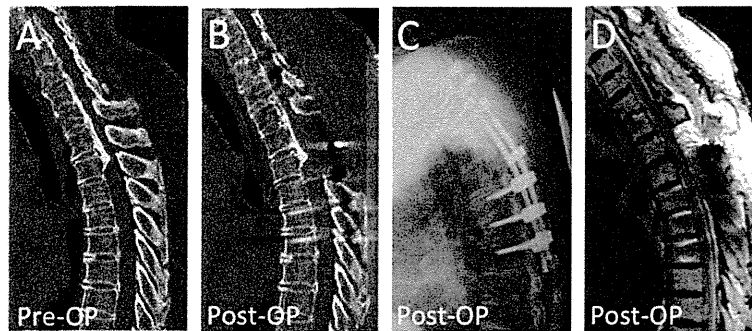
Pre- and postoperative images of Case 1. Pre-operative computed tomography image showed beak-shaped ossification of the posterior longitudinal ligament at T2/3 vertebral level (A). Posterior decompression with instrumented fusion surgery at C7-T5 level was performed (B-D). This patient showed partial paraparesis when she was sitting, but showed immediate neurological recovery after bed rest.
